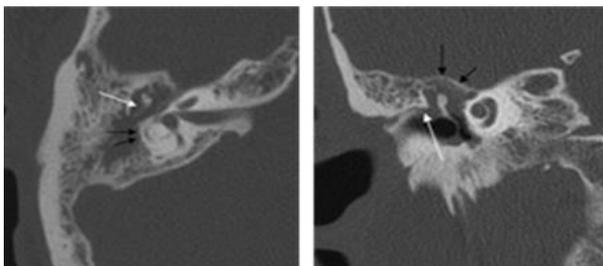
Congenital cholesteatoma* (a) axial section (b) coronal section CT scan of left temporal showed soft tissue mass anterior to the tympanic space (arrow) recorded normal incudostapedial articulation (white arrow in image a) and lateral malleal ligament (white arrow in image b)
